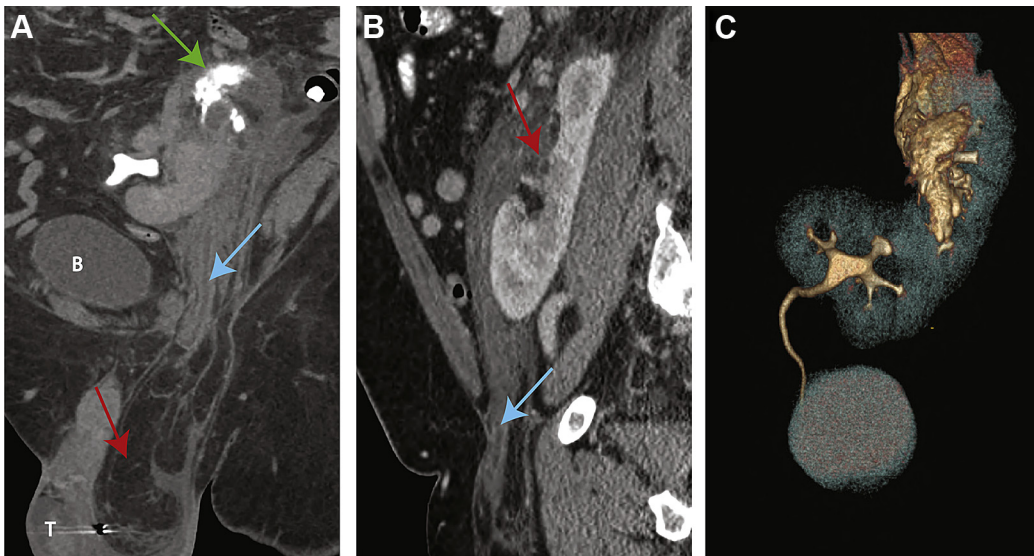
CT urogram showing crossed-fused renal ectopia with left ureteroinguinal herniation. (A) Coronal CT image highlighting the presence of the left ureter (blue arrow) herniating into the inguinal canal and associated indirect inguinal hernia sac (red arrow) with associated left forniceal kidney rupture (green arrow), bladder (B), testicle (T). (B) Sagittal CT image showing left ureteral herniation (blue arrow) and a fused kidney (red arrow). (C) 3D reconstruction of CT imaging showing crossed-fused renal ectopia. The right moiety collecting system inserts normally into the bladder. The left moiety collecting system is distorted on the image due to extravasated urine. No contrast extends into the left ureter due to the extravasation and the obstructed segment in the hernia sac.
